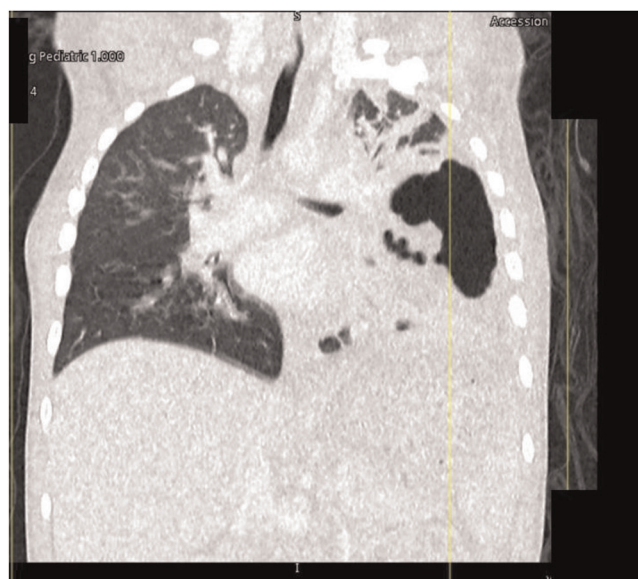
CT chest with contrast Necrotizing pneumonia occupying almost the entire left lower lobe with an expansile multiloculated cavitary mass.
